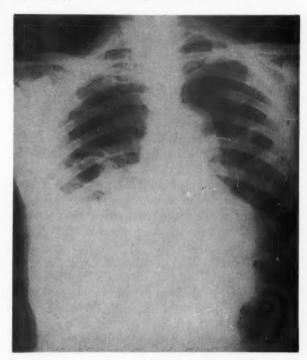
Case 45. X-ray of chest showing right pleural effusion.
